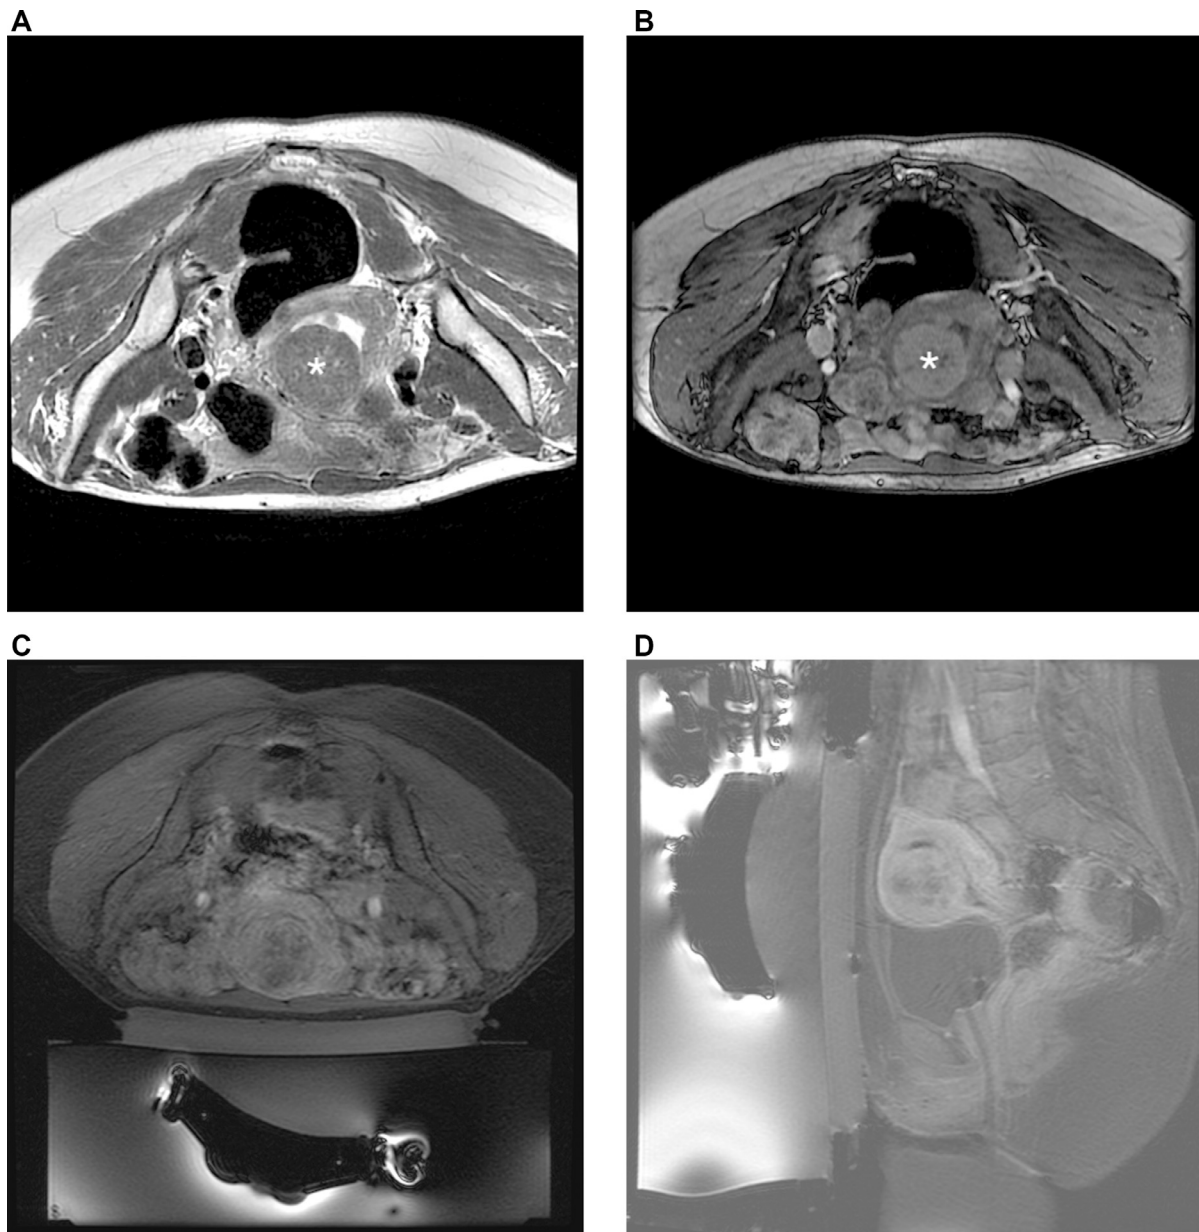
Pre and post-treatment images of a UF in a 40-year-old woman. Pretreatment axial T2-weighted (A) and post-contrast T1-weighted (B) images show a high vascularized intramural myoma located in the anterior wall of the uterus (*white star*). Post-treatment axial (C) and sagittal (D) postcontrast T1-weighted images show the nonperfused area. The procedure was interrupted by the patient before its conclusion because of pain due to a mild skin burn. Calculated NPV was about 20%.
